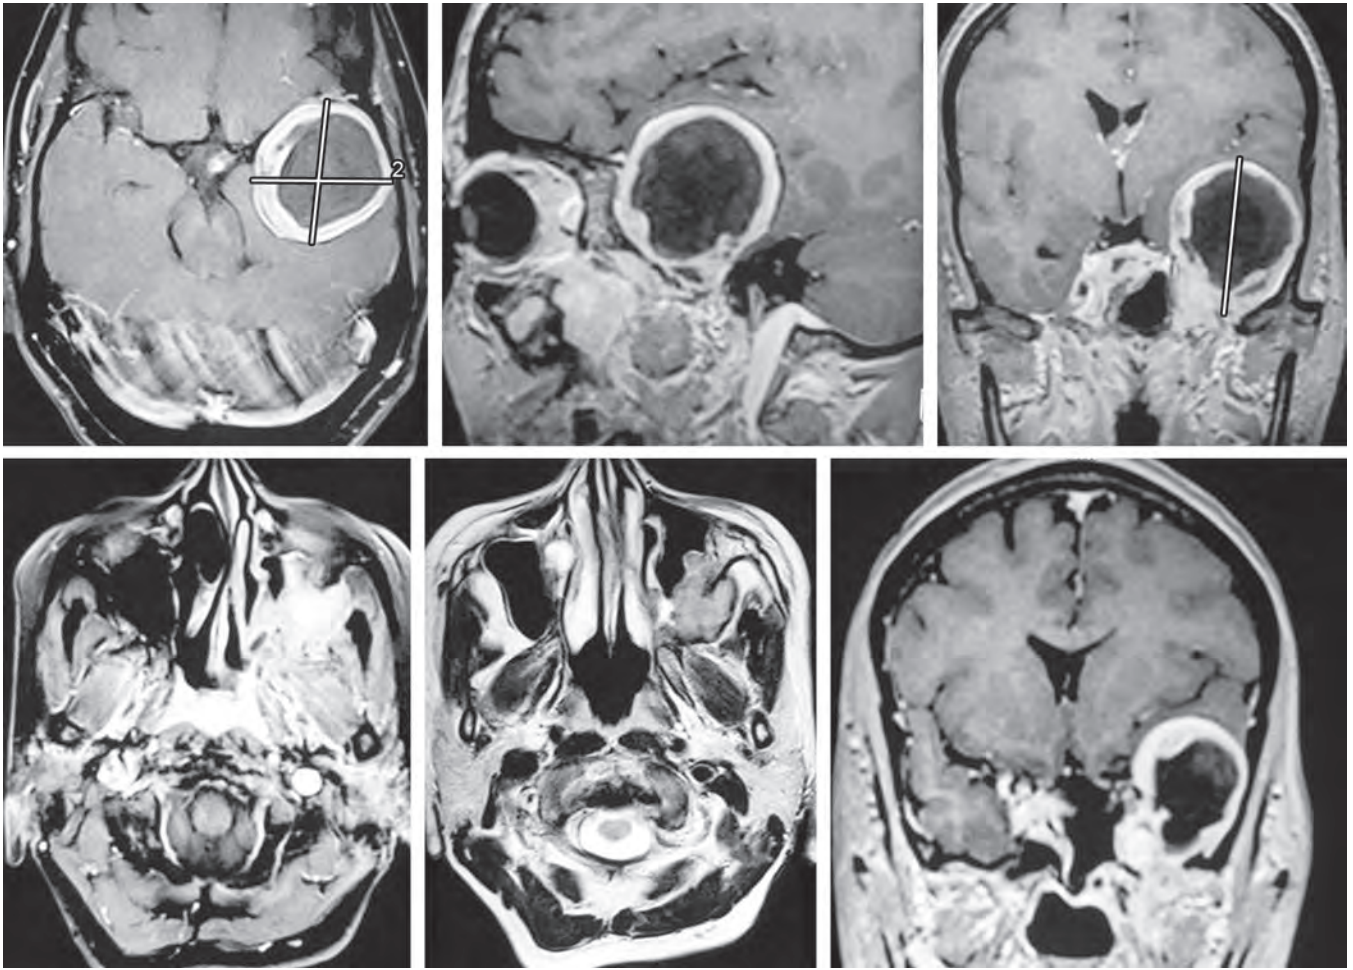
MRI scan of the brain. Well circumscribed extra-axial lesion measuring 4.3 x 4.5 cm in the temporal base with erosion of the skull base and involvement of the dura. There is evidence of the disease in the maxillary sinus (Stage IIIA)
